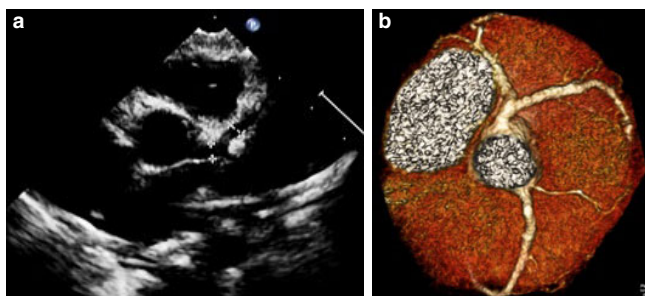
(a) Echocardiogram showing the prominently dilated coronary arteries (left middle coronary artery, 4 mm; left circumflex artery, 2.9 mm) and a fusiform aneurysm of the left anterior descending artery (3 mm). Ectasia was noted in the right coronary artery (2.6 mm). (b) Computed tomography angiogram showing the fusiform aneurysm of the left anterior descending artery with regression of the coronary ectasia.
